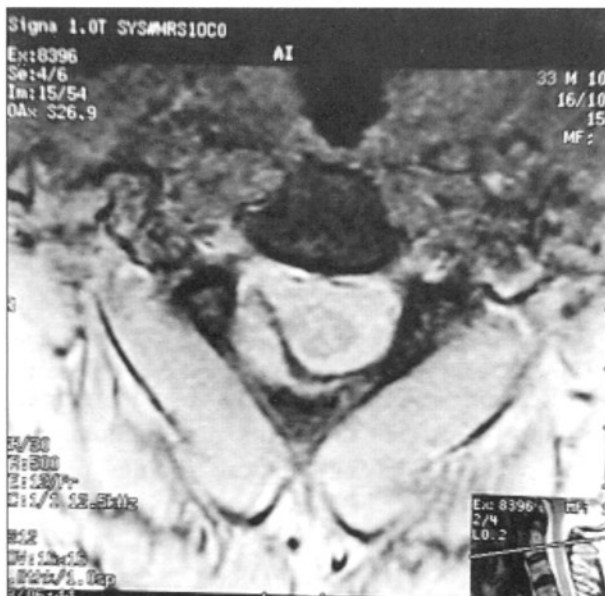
T1-weighted axial MRI without contrast demonstrates a mass lesion at C2 level that is isointense to muscle.
